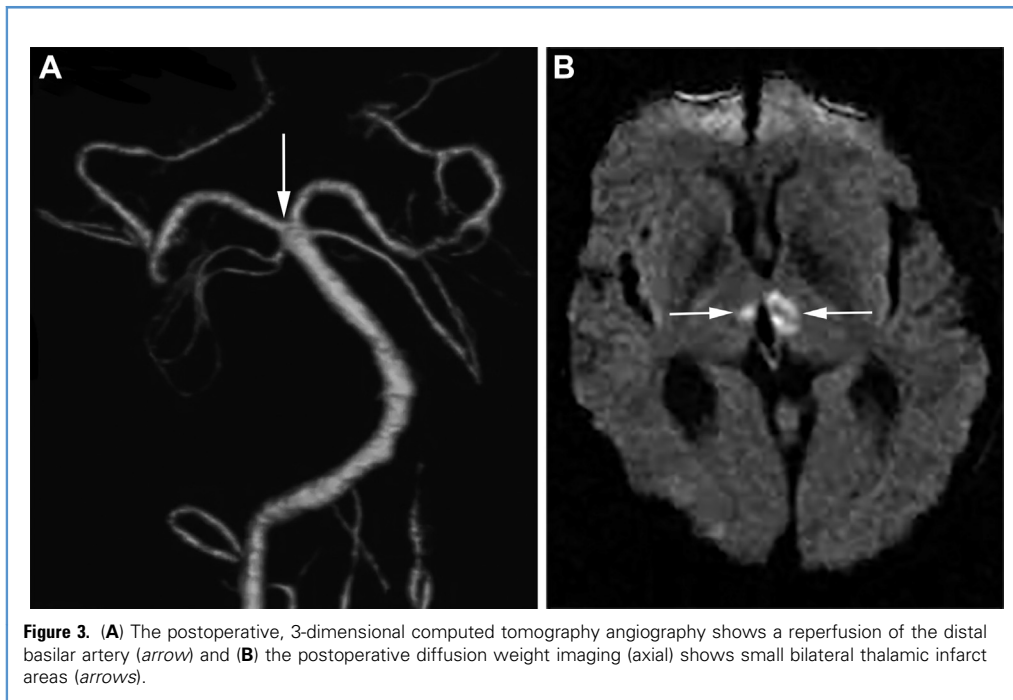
(A) The postoperative, 3-dimensional computed tomography angiography shows a reperfusion of the distal basilar artery (arrow) and (B) the postoperative diffusion weight imaging (axial) shows small bilateral thalamic infarct areas (arrows).
